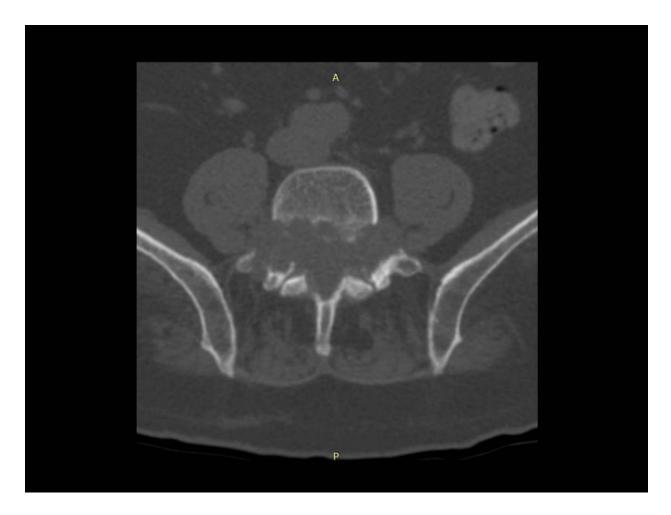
Chordoma. CT shows extensive bone destruction and a large soft tissue mass.
